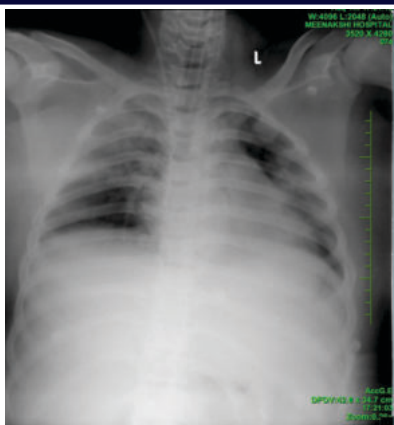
X-ray Of Case 2
